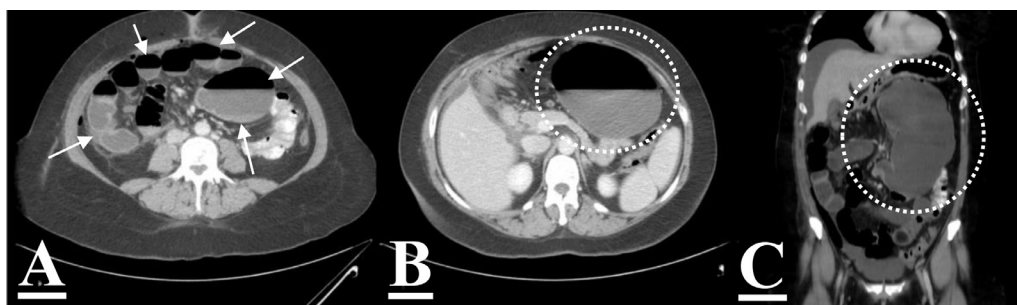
(A) shows an axial view of the abdomen and pelvis CT scan which was done for investigating the intestinal obstruction that occurred post lap cholecystectomy. The white arrows show dilated large and small bowel loops. (B) is an axial view of the abdomen and pelvis CT scan. The white dotted circle shows dilated large bowel loop (cecum). (C) is a coronal view of the abdomen and pelvis CT scan. The white dotted circle shows dilated large bowel loop (cecum) with dilated small bowel loops due to cecal volvulus.
